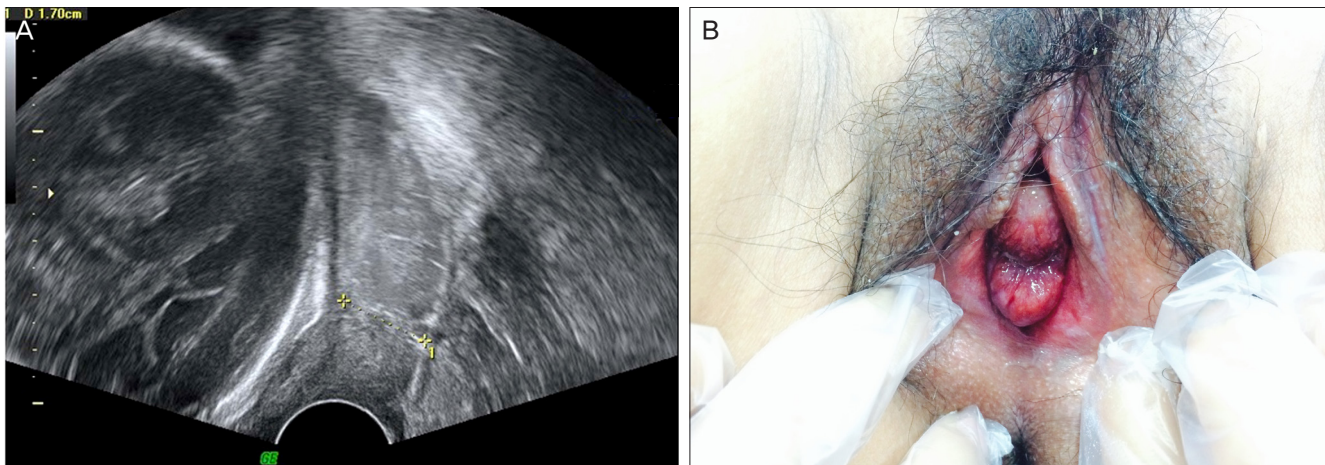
(A) Ultrasonography revealed a short cervix with 17-mm length and a T-shape. (B) Physical exams show second-degree uterine prolapse. The eroded cervix projected through the vaginal introitus.
